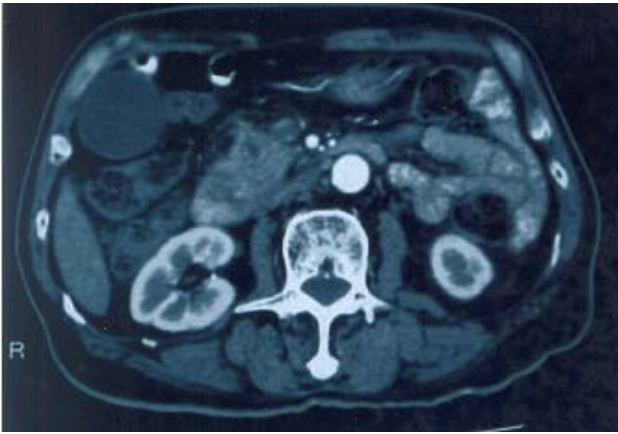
CT scan of the abdomen of patient A shows vaguely the dilated pancreatic (small arrow) and common bile duct (big arrow), but no definite pancreatic mass was seen.
